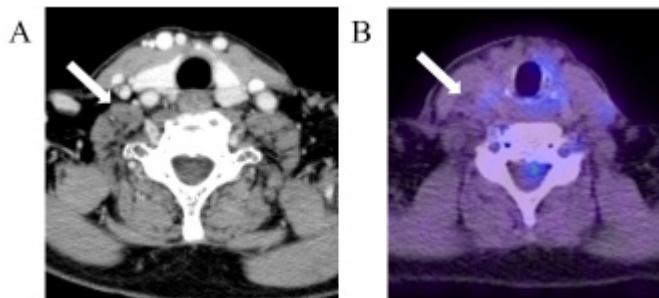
Contrast-enhanced computed tomography image showing improvement of the metastatic lymph node mass 2 years after discontinuation of chemotherapy (A, arrow). 18F-fluorodeoxyglucose (FDG)-positron emission tomography-computed tomography image showing disappearance of the FDG accumulation in the primary lesion and N3 cervical lymph node (B, arrow).
